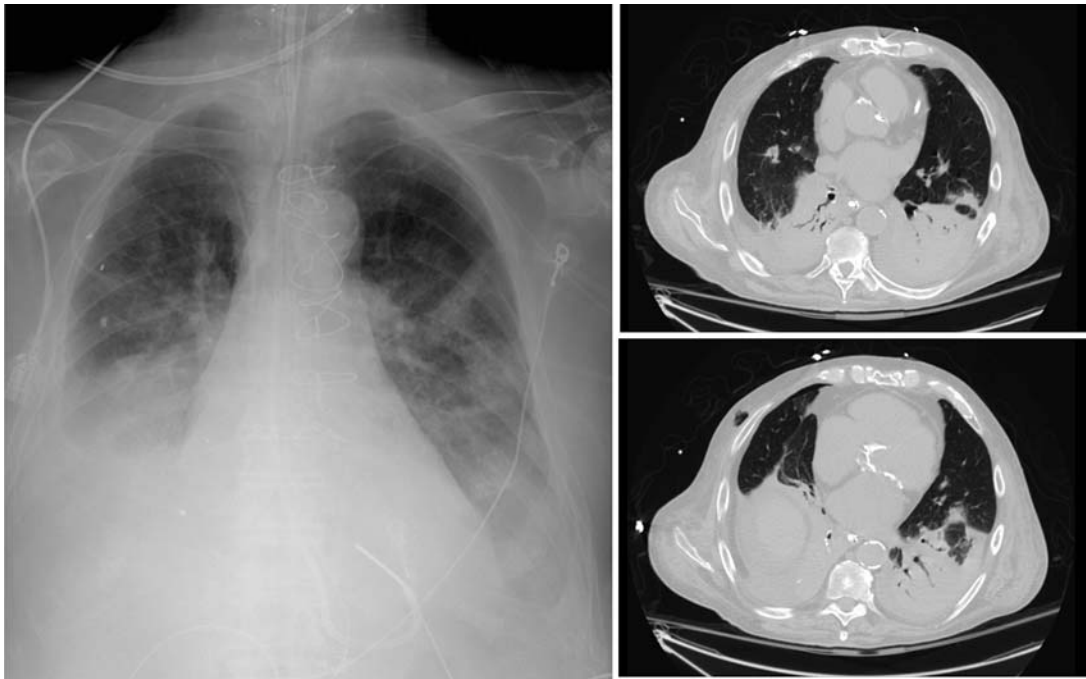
Intrapulmonary and extrapulmonary causes of postoperative respiratory failure. Eighty-year-old man with COPD and aortic valve replacement underwent small bowel resection and repair of traumatic diaphragmatic hernia. Six days after surgery he developed respiratory distress caused by atelectasis, atrial fibrillation, volume overload, and aspiration. Following intubation, chest radiograph (left) demonstrated discoid atelectasis in the left upper lung zone, pleural effusions, and pulmonary infiltrates. Computed tomography (right) revealed air space opacities suggestive of pneumonia and lower-lobe atelectasis.
